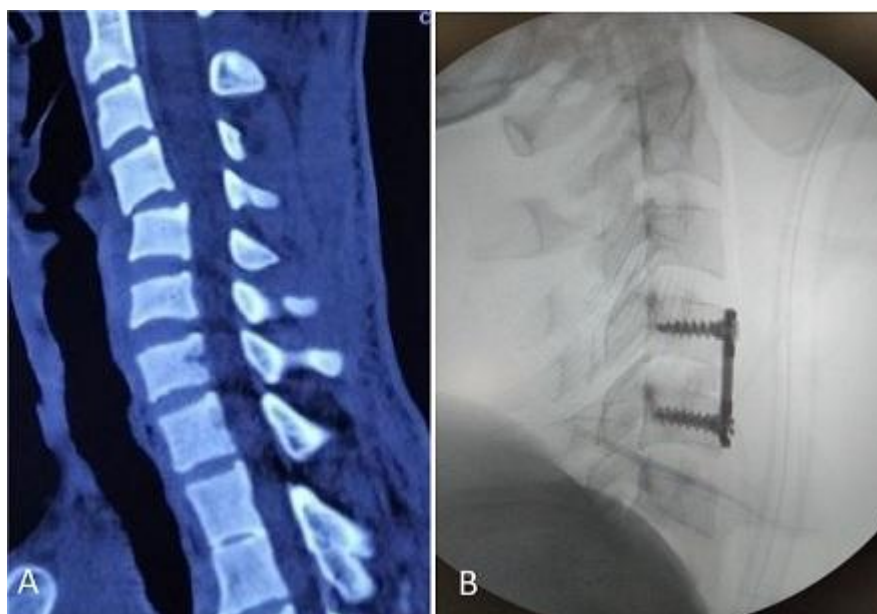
A) C4/5 dislocation in CT in sagittal reconstruction. B) Fluoroscopic control at the end of surgery (C5 discectomy, interbody autologous graft and fixation with C4-5 plate and screws).
